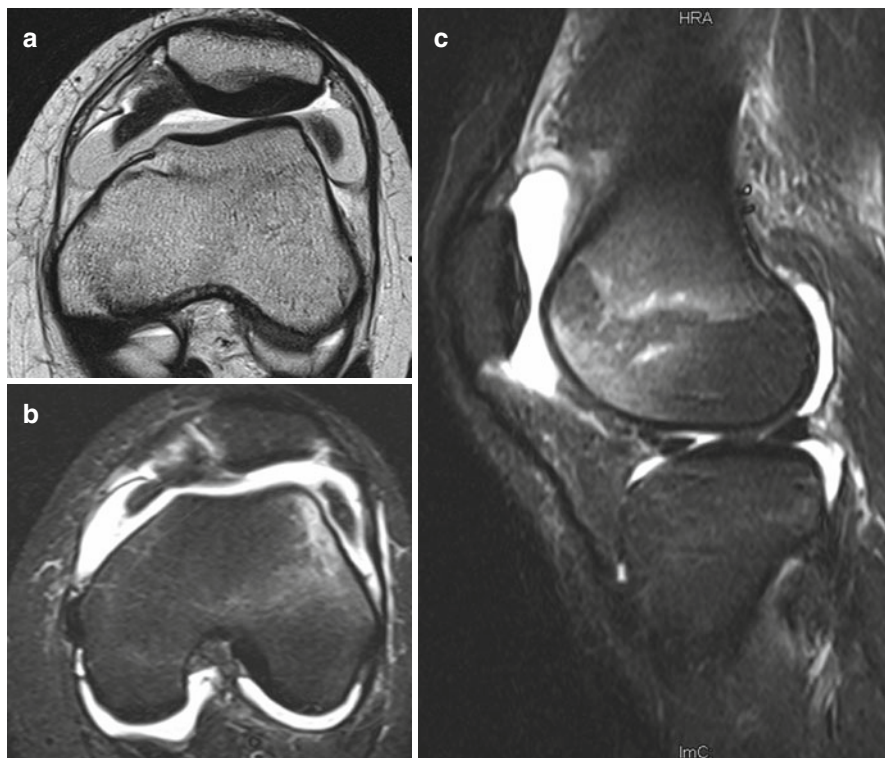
A 15-year-old female patient affected by patella luxation spontaneously reduced. (a) T2-weighted image on axial plane shows lipohemarthrosis with three layers visible (from above: fat, fluid, and red blood cells). (b, c) STIR sequences obtained on the sagittal and axial plane show bone marrow edema on the lateral aspect of the external femoral condyle and on the patella medial aspect, as a consequence of sesamoid luxation
